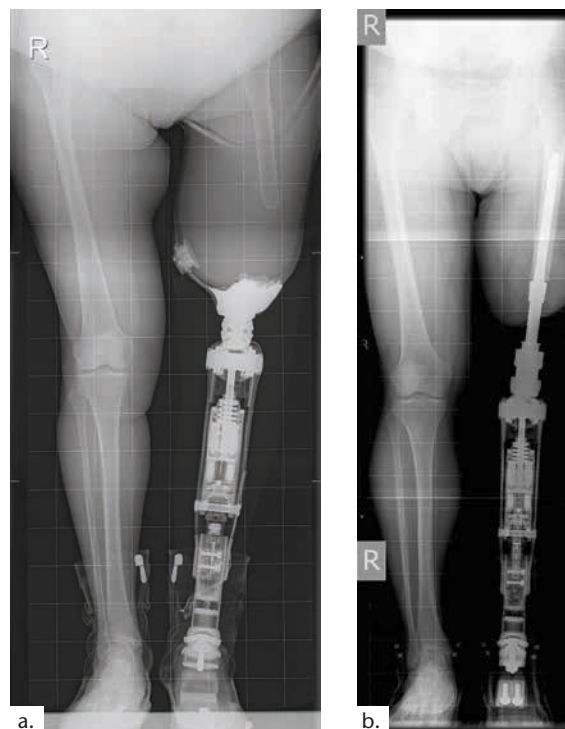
X-ray with socket prosthesis.
